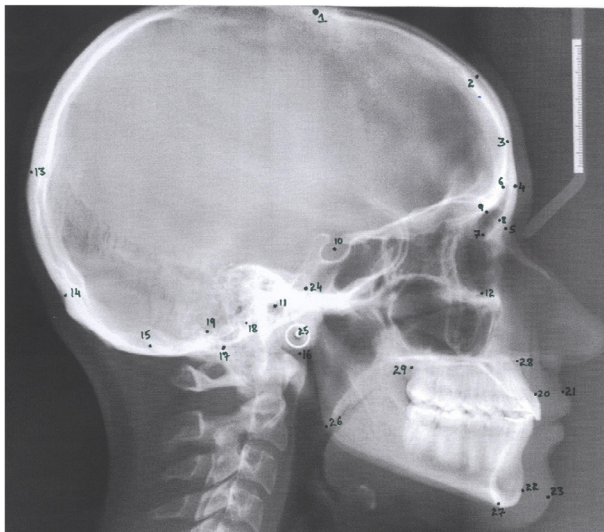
Cephalometric landmarks plotted on radiograph.
